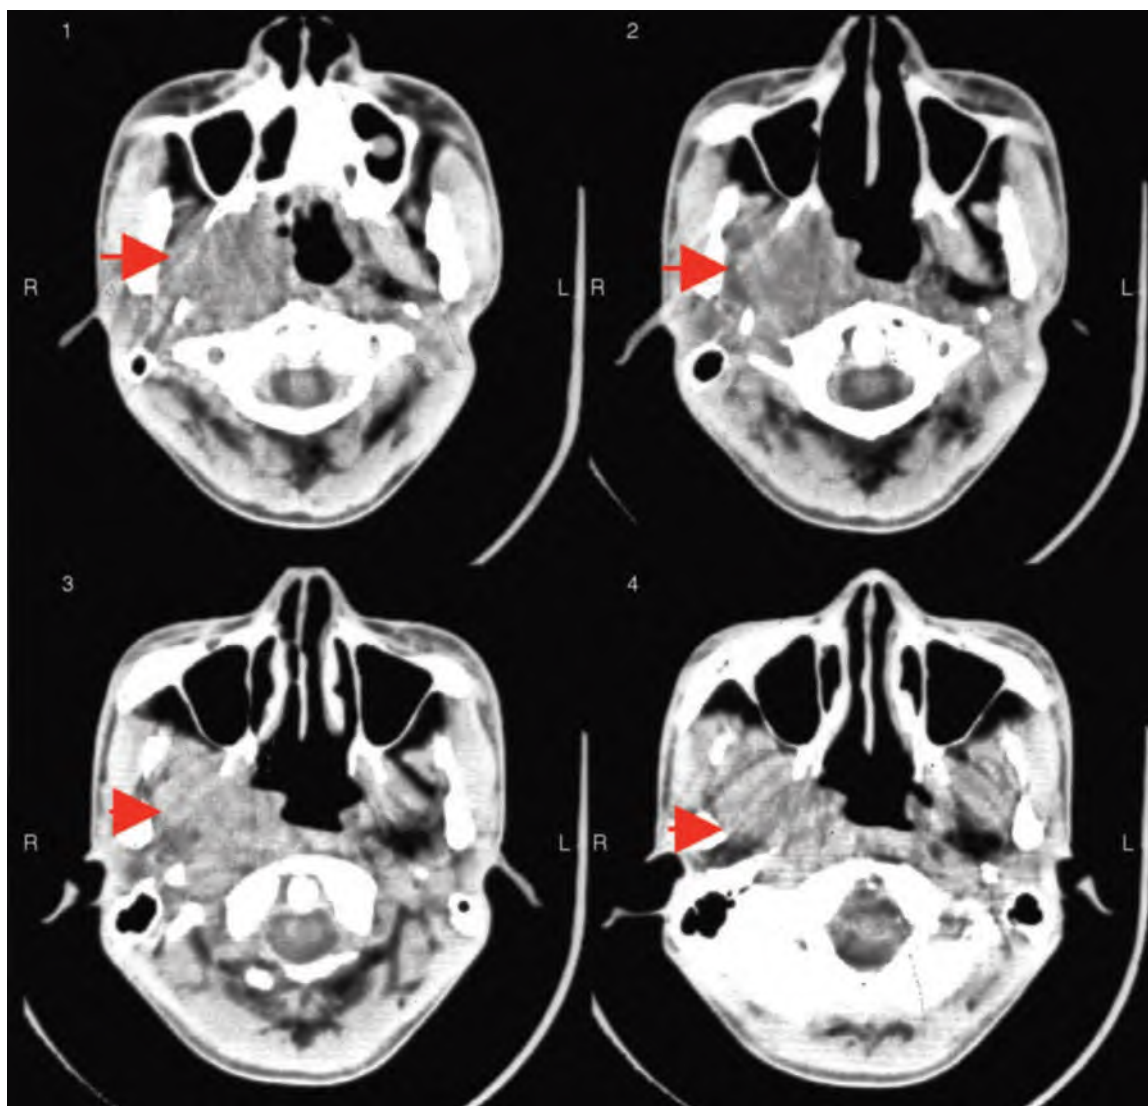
Computed tomographic scan images of 25-year-old man with nasopharyngeal carcinoma (arrows). Tumor involves right parapharyngeal space. (Courtesy Dr. Yi Zeng.)
